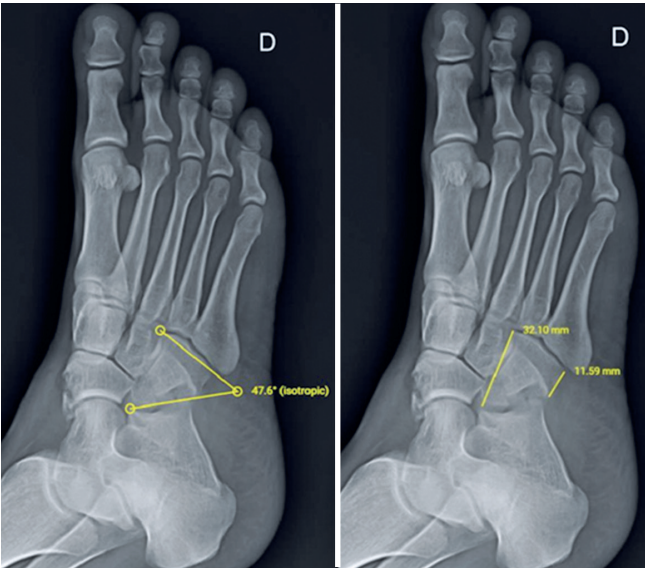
Radiographs with fracture-impaction of the cuboid. Alpha angle = 47.6° and cortical ratio = 0.36°.
